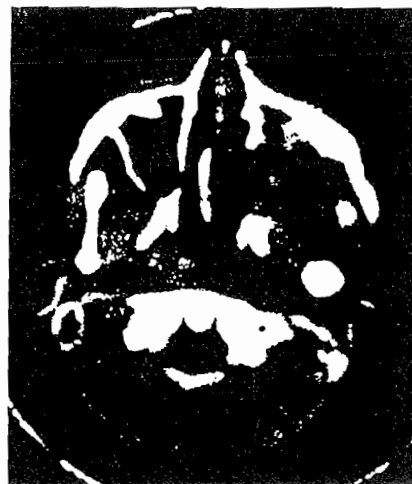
d Computed tomography
